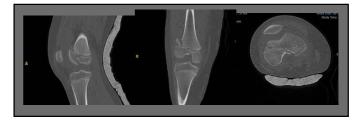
Preoperative computed tomographic scan sagittal, coronal, and axial views demonstrate comminuted distal femur triplane fracture
